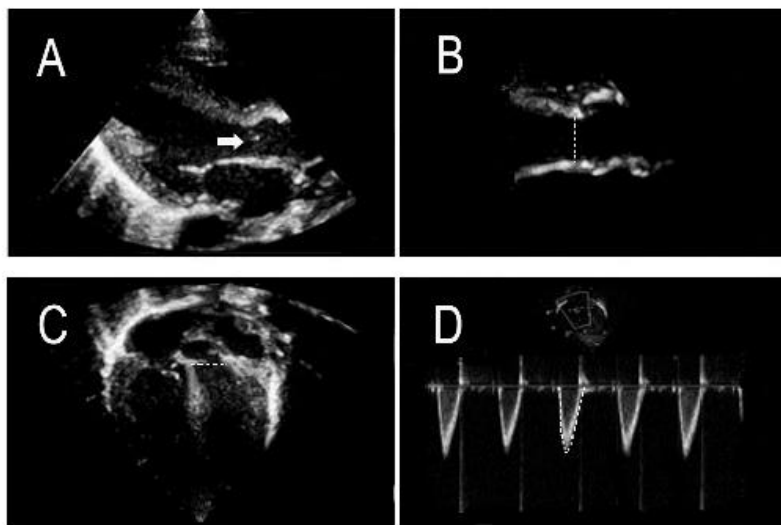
Assessment of left ventricular output. LVOTD is measured from parasternal long-axis view (a,b). VTI is acquired in the apical five chamber view (c,d)
